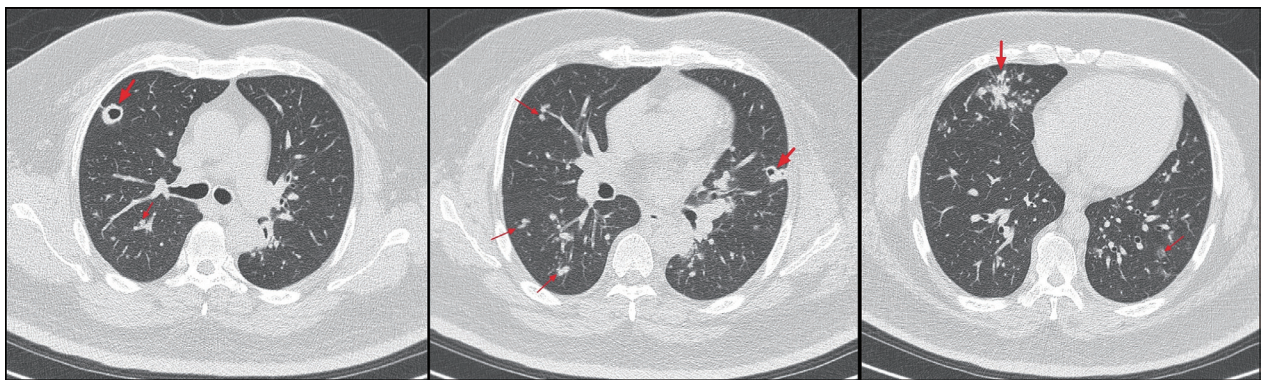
The regions with cavities (diameter: a 17 mm cavity at the right upper lobe and a 12 mm cavity at the left upper lobe) and nodules were seen in the chest computed tomography series in the axial view before treatment.
